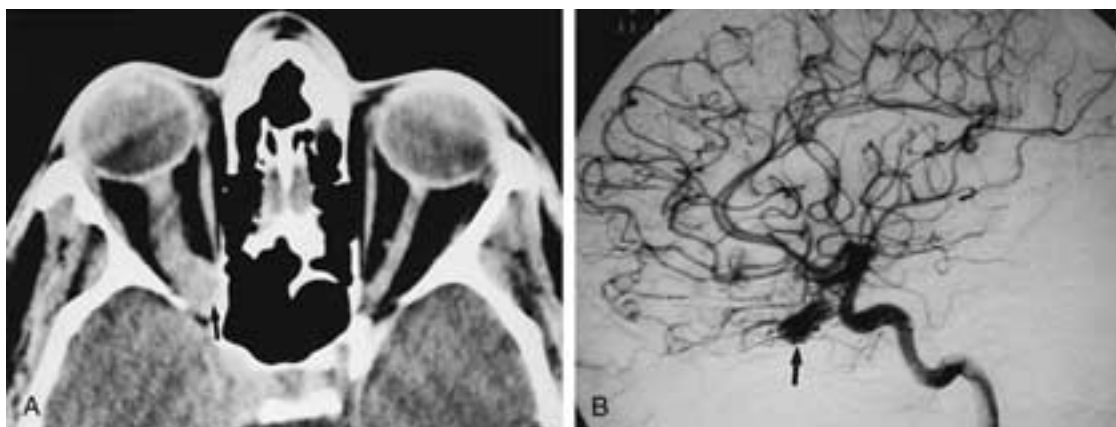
Optic nerve hemangioblastoma. Enhanced axial CT scan (A) and lateral angiogram (B) showing an optic nerve hemangioblastoma (arrows). (From Mafee MF et al. Optic nerve sheath meningiomas: role of MR imaging. Radiol Clin North Am 1999;37:37–58.)
